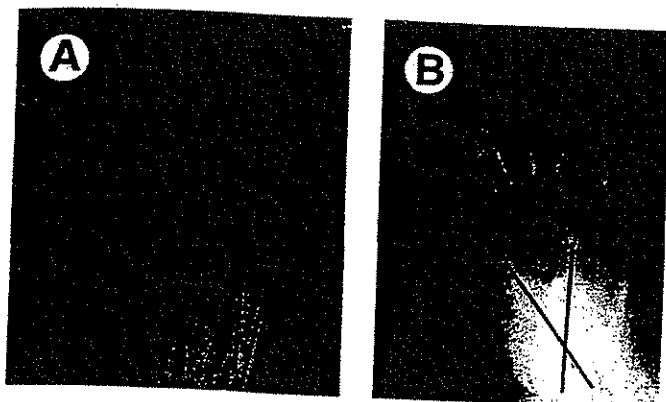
Dorsoplantar radiographs of congenital clubfoot (A) before and (B) after correction by using the Ponseti method, showing correction of the talocalcaneal angle.
